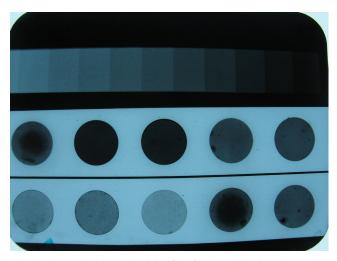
Radiograph with sample disks of the freshly prepared study materials and the aluminum step wedge
